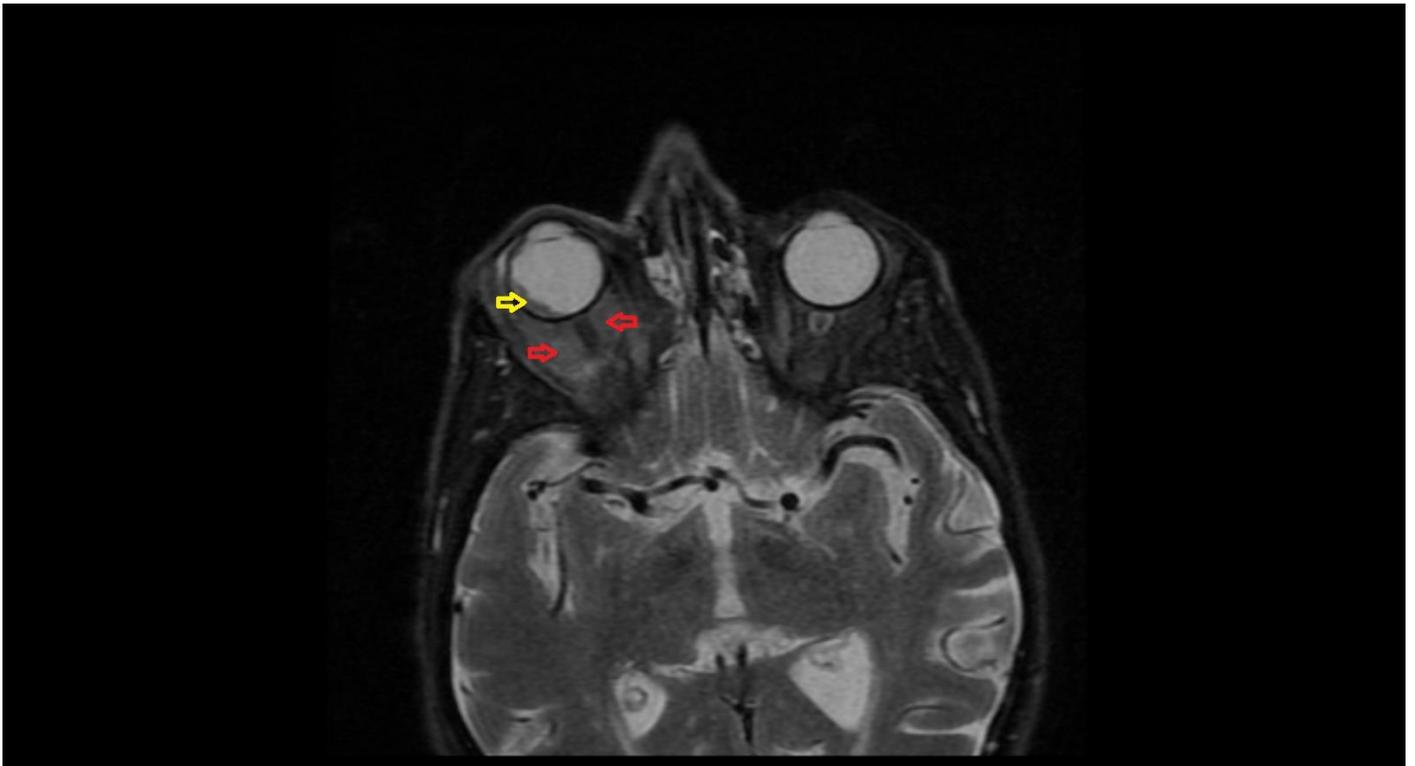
The axial T2-weighted fat suppressed MRI scan of optic nerve sheath meningioma (red arrow) and globe invasion (yellow arrow)
